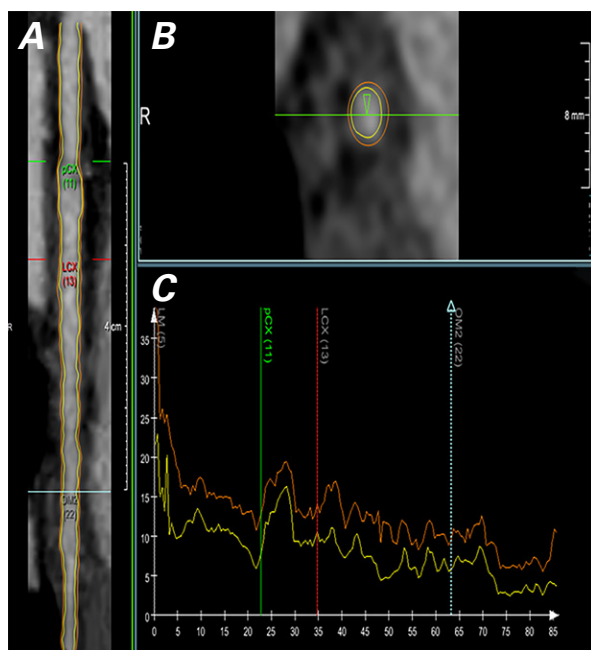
Using coronary computed tomographic angiography, we summed individual segment plaque volumes in all available vessels to obtain total plaque volumes for each scan. Images show the left circumflex coronary artery (LCx) from the left main coronary artery to the 2nd obtuse marginal branch (OM2) in A) longitudinal and B) cross-sectional views. C) Tracings show vessel and luminal areas.
